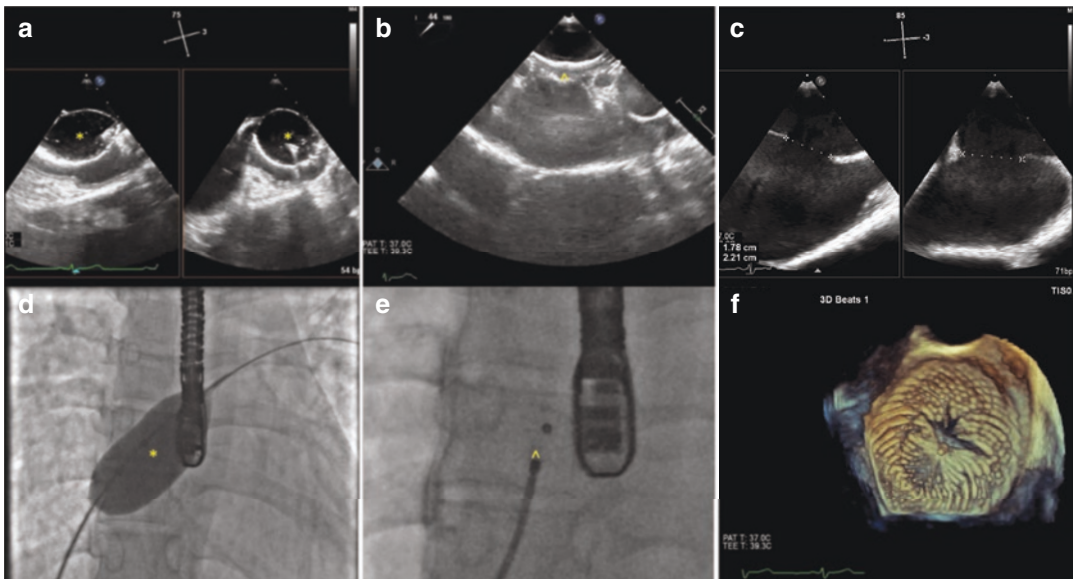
Closure of an Atrial Septal Defect with an Amplatzer Septal Occluder. (a, d) Balloon sizing of the atrial septal defect. The top pane (a) is an X-plane of the atrial septal defect with transesophageal echocardiography (TEE) imaging during balloon occlusion of the defect with a sizing balloon. The bottom pane (d) is a fluoroscopic image of the sizing balloon across the atrial septal defect. There is a slight waist. (b, e) Deployment of the Amplatzer Septal Occluder. The top pane (b) is a TEE
